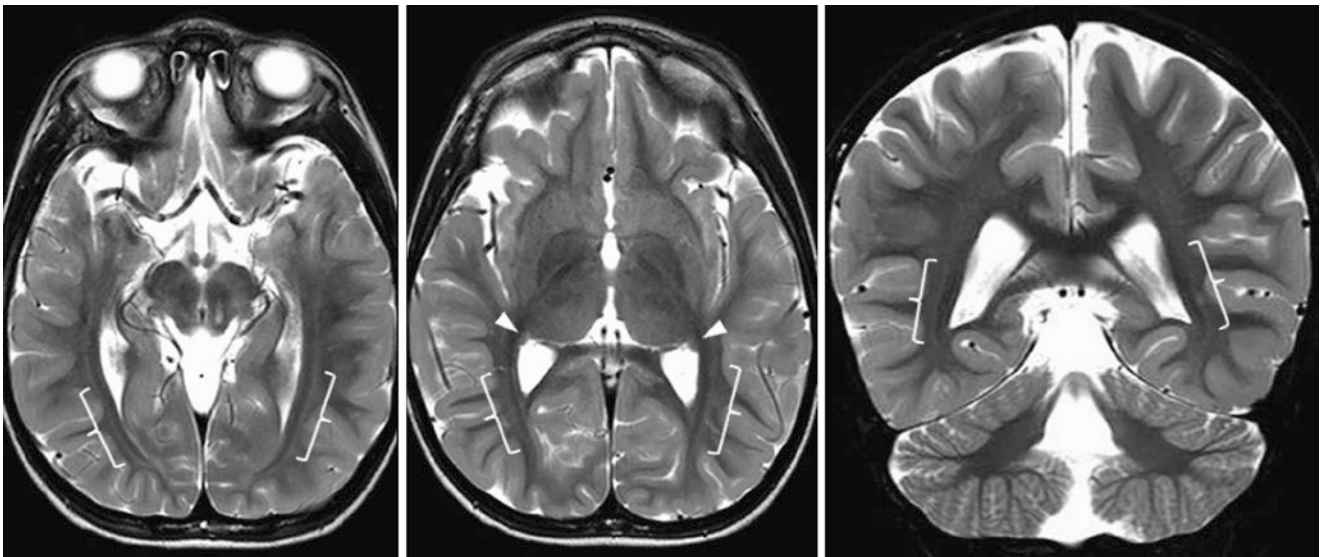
A 4.0-year-old with altered mentation. A 3T MRI with SE T2WI in axial (*left and middle*) and coronal (*right*) planes demonstrated terminal zones in the optic radiations (*brackets*), being normal for age. Note normal caudate tails (*arrowheads*)
